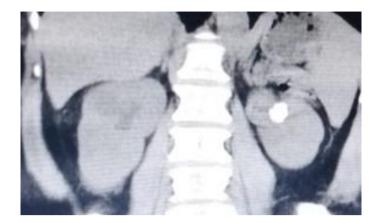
Contrast enhanced coronal reformatted CT scan of the kidneys showing a hyperdense focus (calculus) in the middle pole of the left kidney
